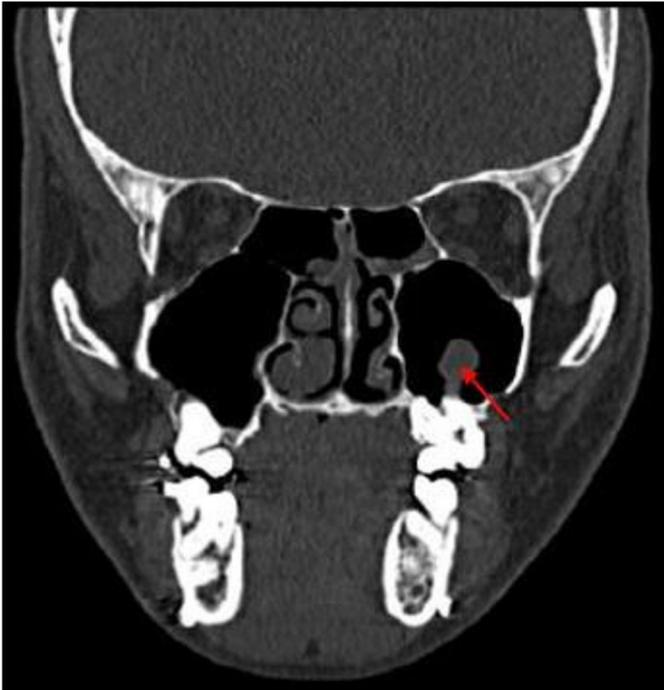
Postoperative coronal CT image showing persistent unilateral maxillary sinusitis on left side (arrow).
